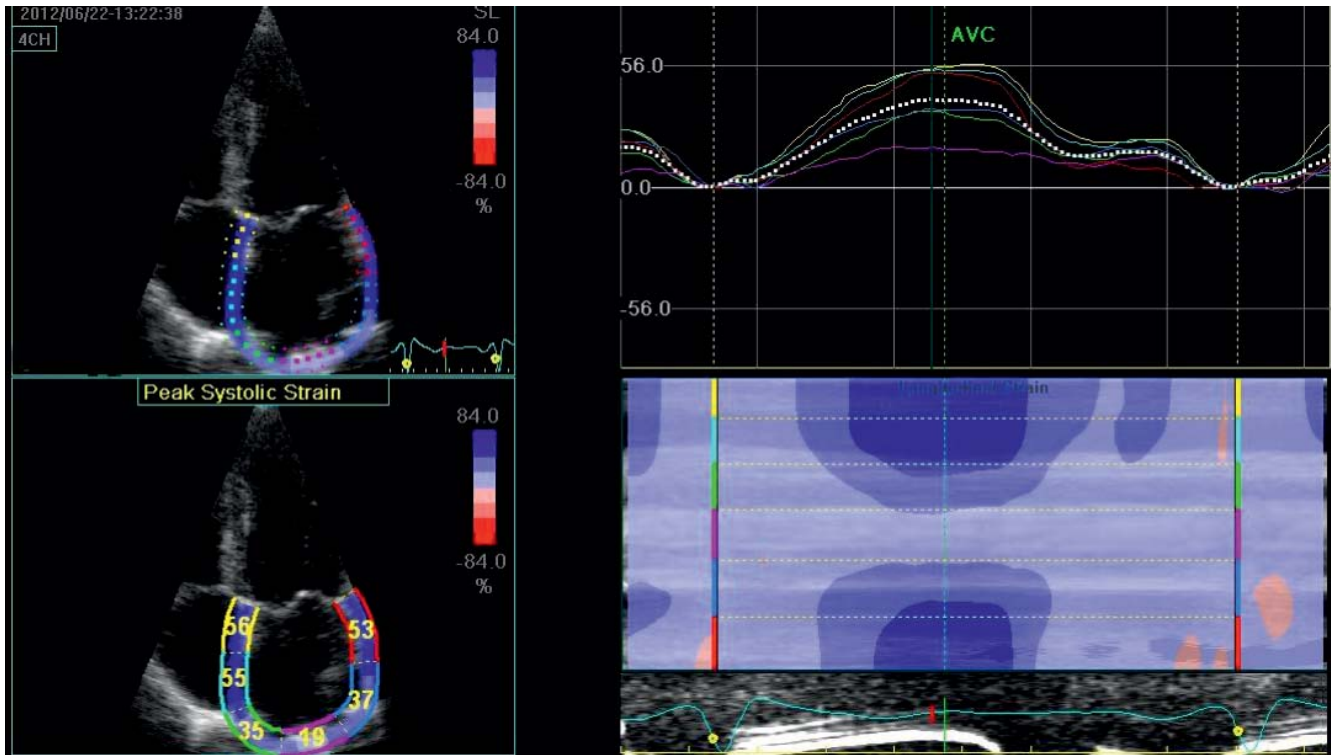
Assessing left atrial strain in apical 4c view.
